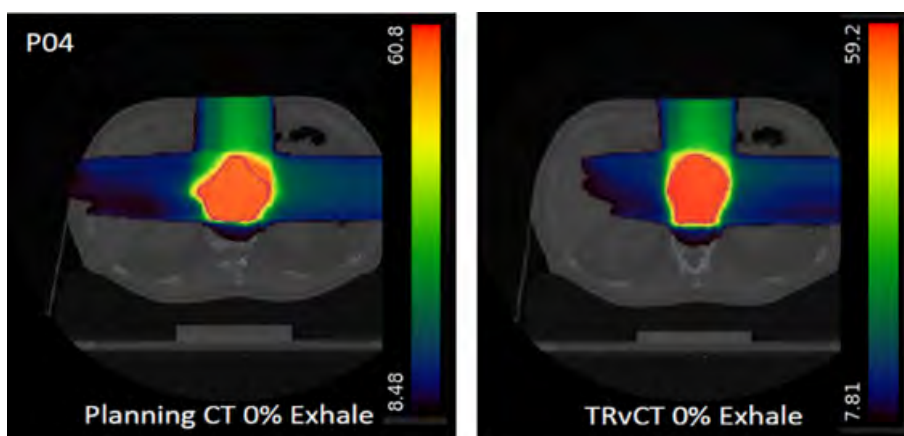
Planning 0% exhale CT overlaid with planning dose map (left); generated TRvCT volume overlaid with accumulated dose distribution (right). Corresponding CTV contours are shown in dark red colour.
